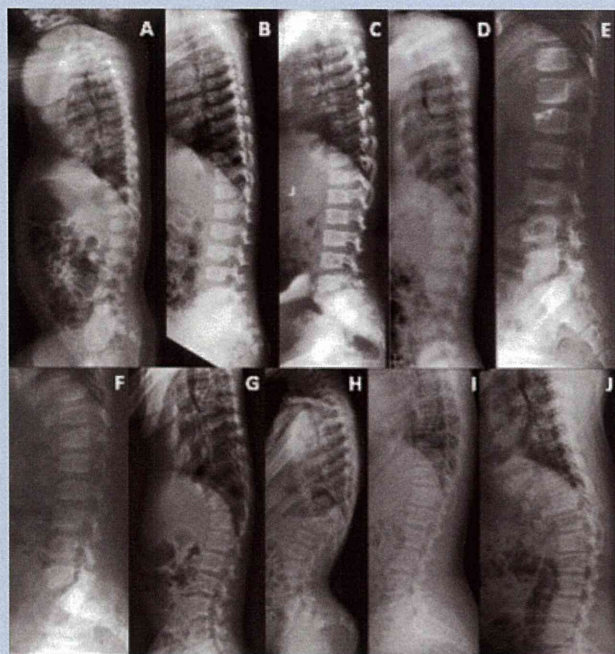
Radiographs of spine. A: Patient 1 at age 6 months. The vertebral bodies are somewhat ovoid, but platyspondyly is not evident. B: Patient 2 at age 1 ⁴/₁₂ years, (C) Patient 3 at age 4 years, (D) Patient 4 at age 5 years. Mild platyspondyly is evident. E: Patient 6 at 8 age years, (F) Patient 7 at age 10 years, (G) Patient 4 at age 10 years, (H) Patient 5 at age 12 years. Platyspondyly is most conspicuous in late childhood. I: Patient 6 at age 15 years, (J) Patient 7 at age 23 years. Platyspondyly is discernible but milder than that in childhood.
